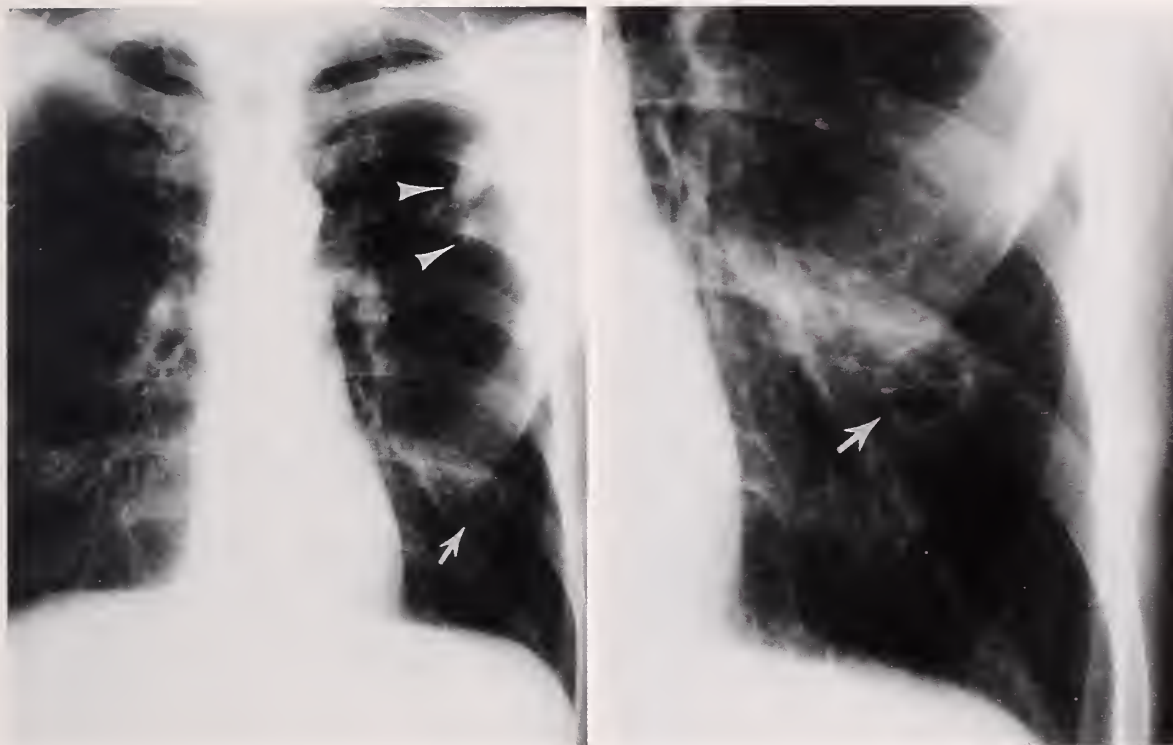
(A) Chest radiograph of 50-year-old man with combined *Mycobacterium avium* and *Coccidioides immitis* disease shows 2 left upper lobe pulmonary nodules from *M avium* (arrowheads) and a thin-walled cavity in the left lower lobe from *C immitis* (arrow). Surgically confirmed. (B) Close-up of thin-walled cavity in left lower lobe from *C. immitis* (arrow).
